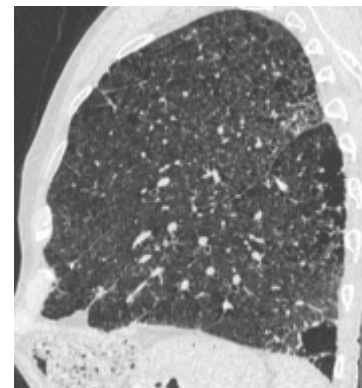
Combined pulmonary fibrosis and emphysema (CPFE). Sagittal CT scan shows emphysema in the upper lobes and fibrosis in the lower lobes, a combination called CPFE, a distinct clinico-radiologic entity.
